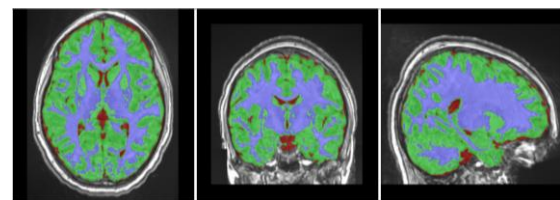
The tissue classification used T1-MRI data in three slice viewer, from left to right (Transverse, Coronal, and Sagittal view, respectively)
